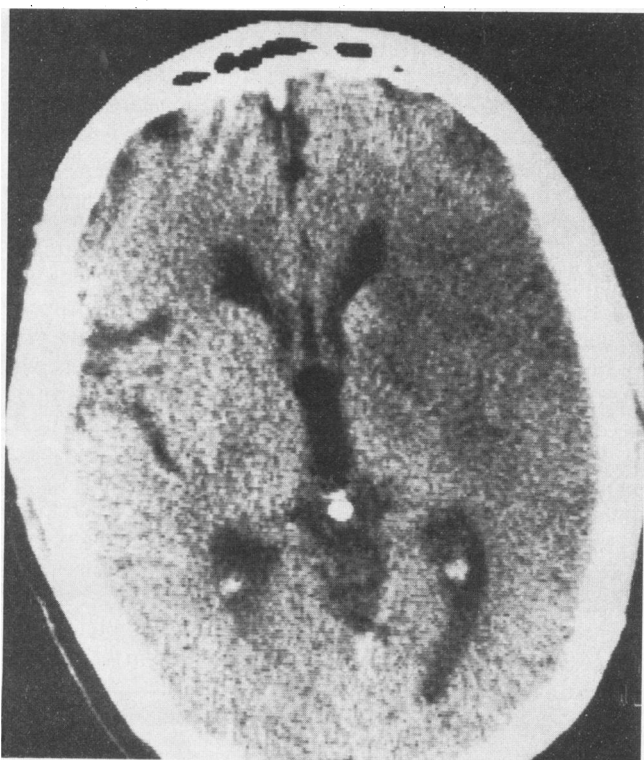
An unenhanced computed tomographic scan shows a nonhemorrhagic low-density lesion on the left.
